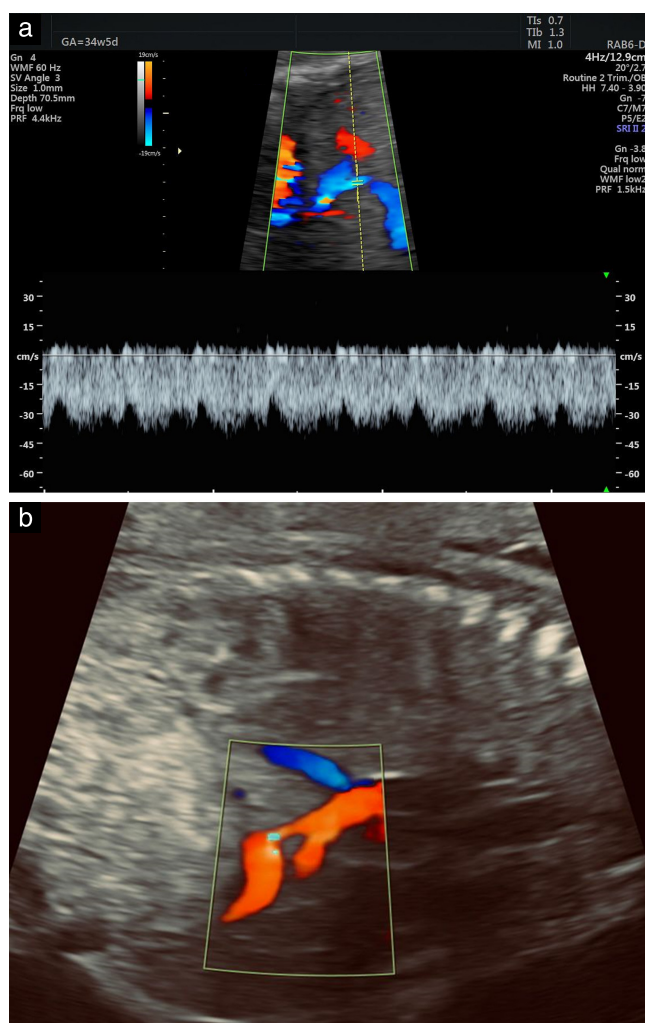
Doppler waveform from ductus venosus obtained transabdominally in third trimester: transverse (a) and longitudinal (b) sections of fetal abdomen.
